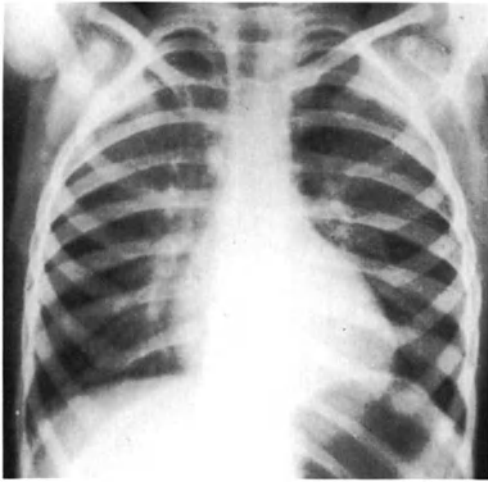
Patent ductus arteriosus in posteroanterior upright film. Narrow pedicle, aortic arch not prominent, left ventricular hypertrophy with radiographically visible enlargement as a result of left ventricular volume overload.
